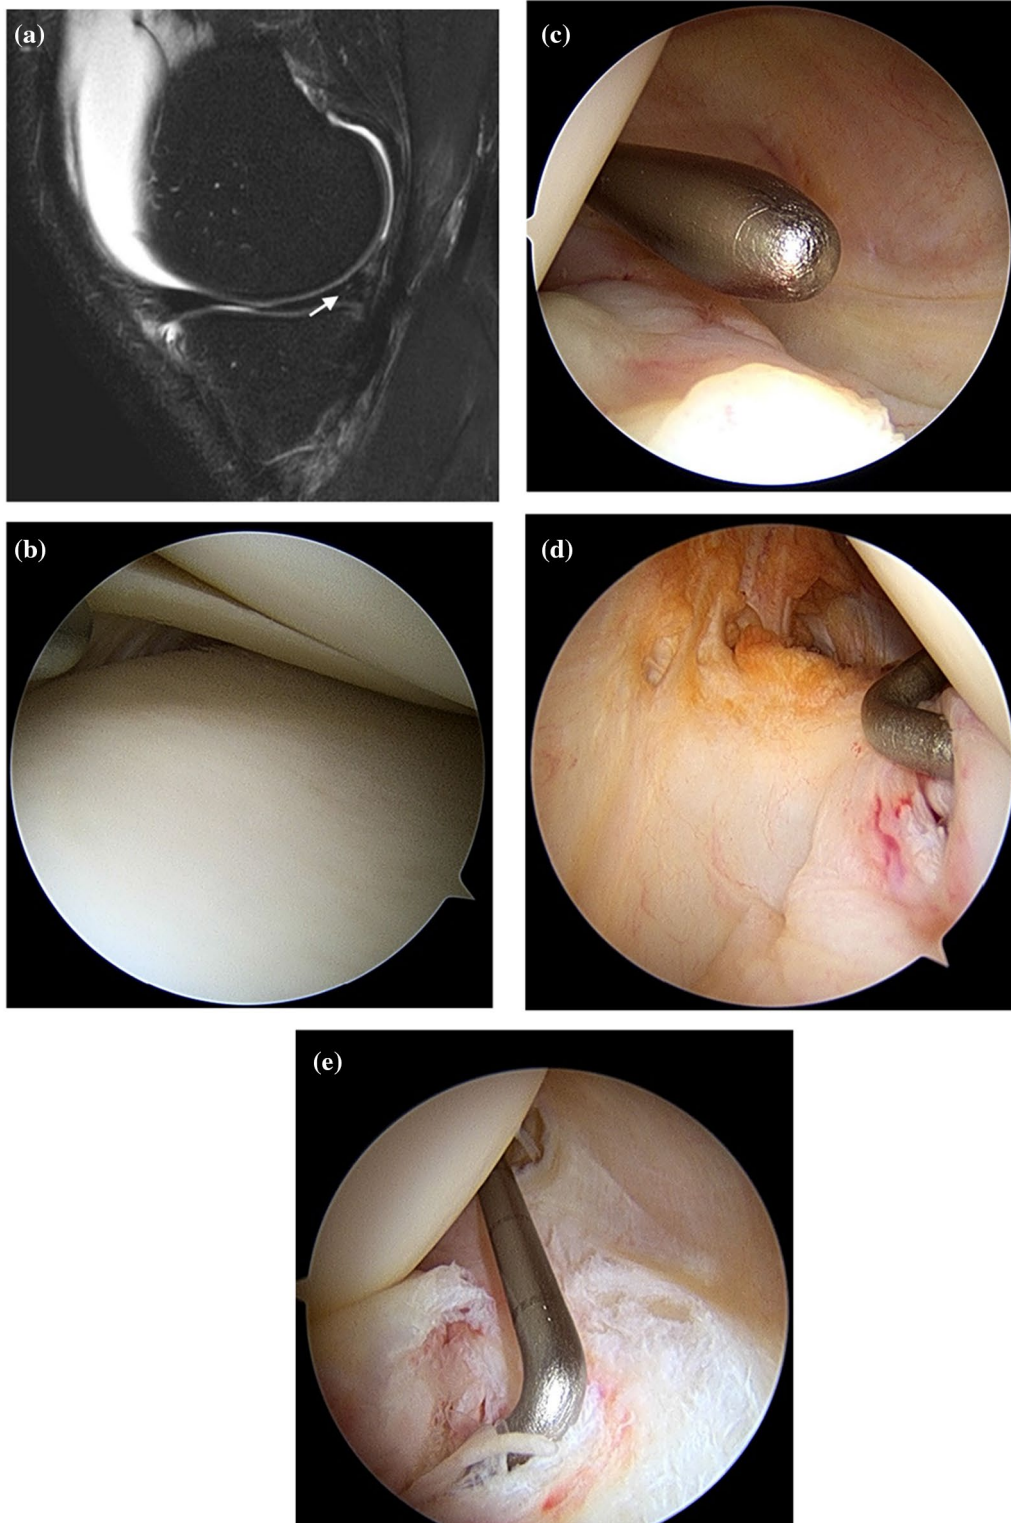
A Ramp lesion in an ACL-injured knee on the sagittal plane of preoperative MRI. The signal intensity (white arrow) at PHMM was high, but it was uncertain whether there was a definite tear. B Anterior view using 30° arthroscopy. The medial meniscal tears were not confirmed during the anterior view examination using 30° arthroscopy and probing. C Transcondylar notch view using 30° arthroscopy. It was uncertain whether there was a definite tear in the peripheral area of the PHMM. D Posteromedial (PM) portal view using 70° arthroscopy. The tear was confirmed by probing through the transcondylar notch with a posteromedial portal view using 70° arthroscopy. E Transcondylar notch view using 70° arthroscopy. Ramp lesions could be easily identified
